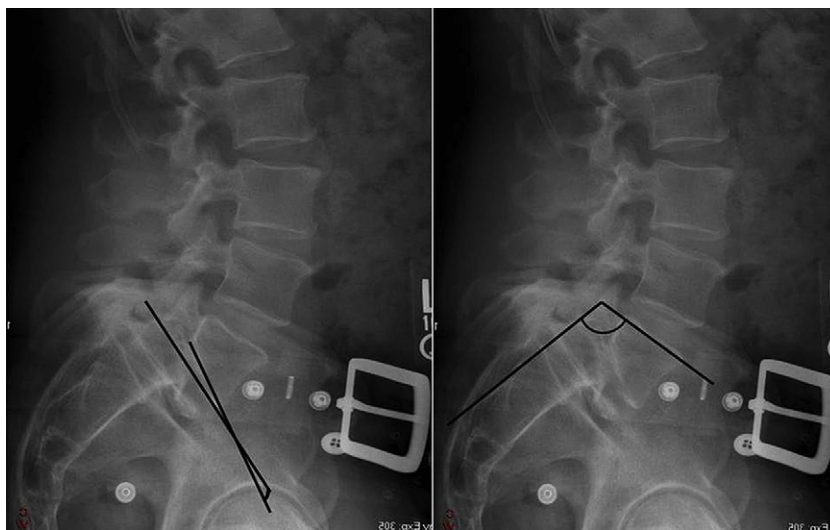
Lateral radiograph demonstrating measurement of Boxall slip angle (*left*) and Dubousset lumbosacral angle (*right*).
